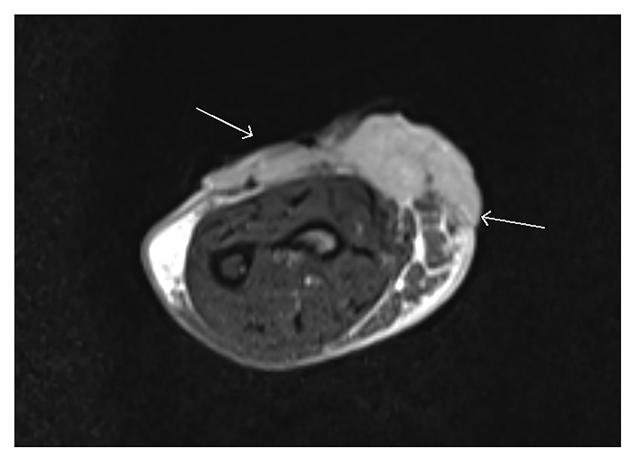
T2-weighted magnetic resonance imaging precemiplimab treatment axial slice showing ulceration through the subcutaneous fat and fascia with invasion into the brachioradialis muscle.
